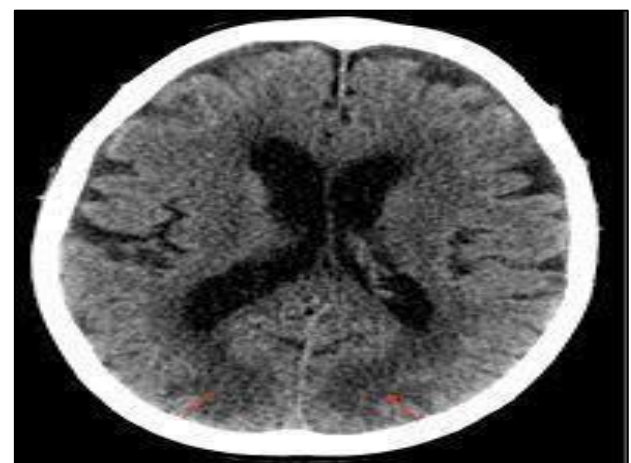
CT scan showing low attenuation of posterior cortical areas.
